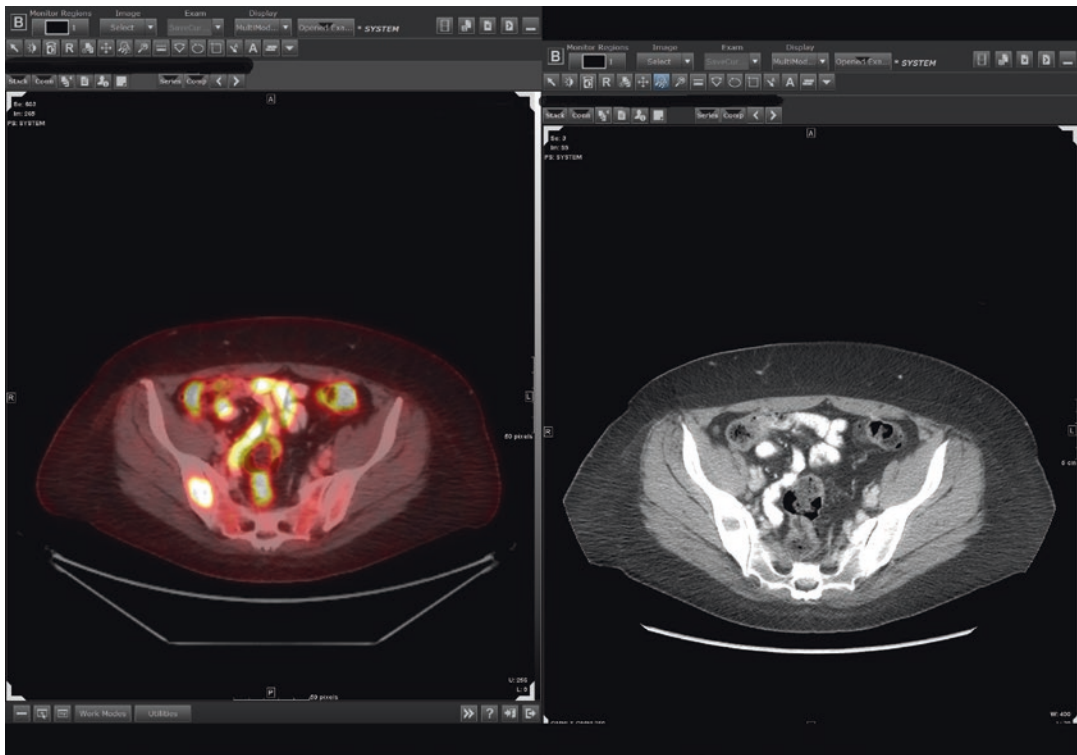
Rosai–Dorfman disease of the bones: axial-fused FDG-PET/CT demonstrates a hypermetabolic lesion in the right iliac bone (Courtesy of Dr. Eli Diamond, New York, USA)
